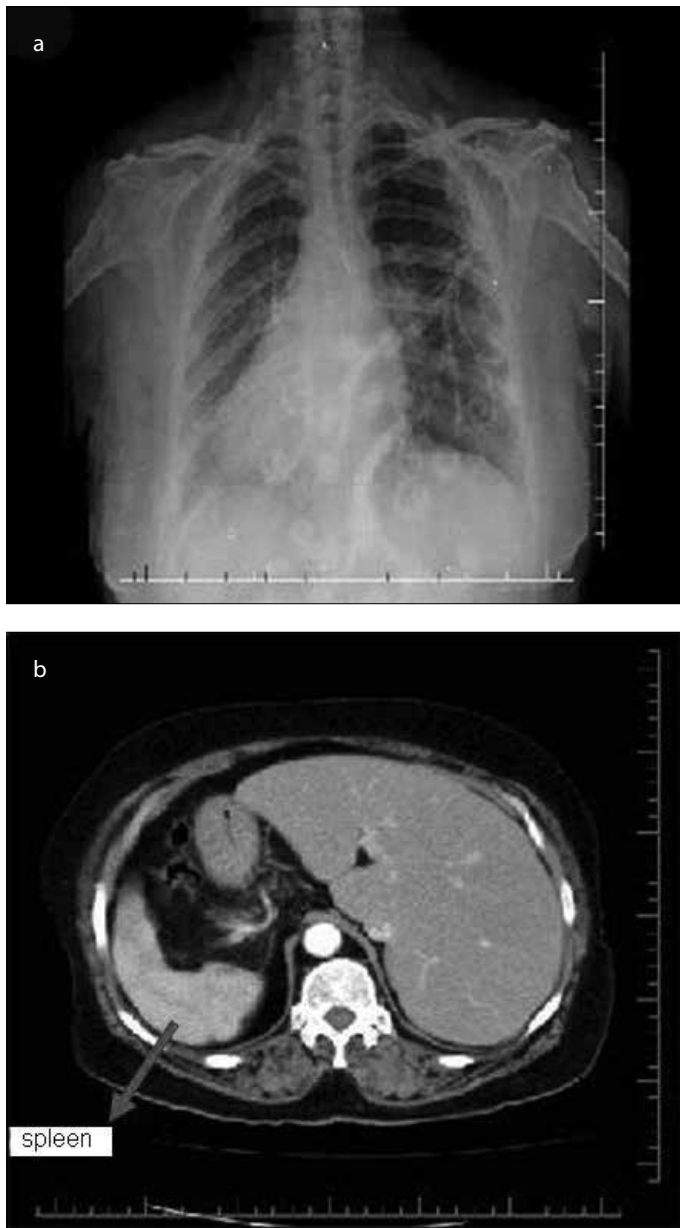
a, b. Posterior–anterior chest X-ray (a) and abdominal tomography (b) image of the patient
